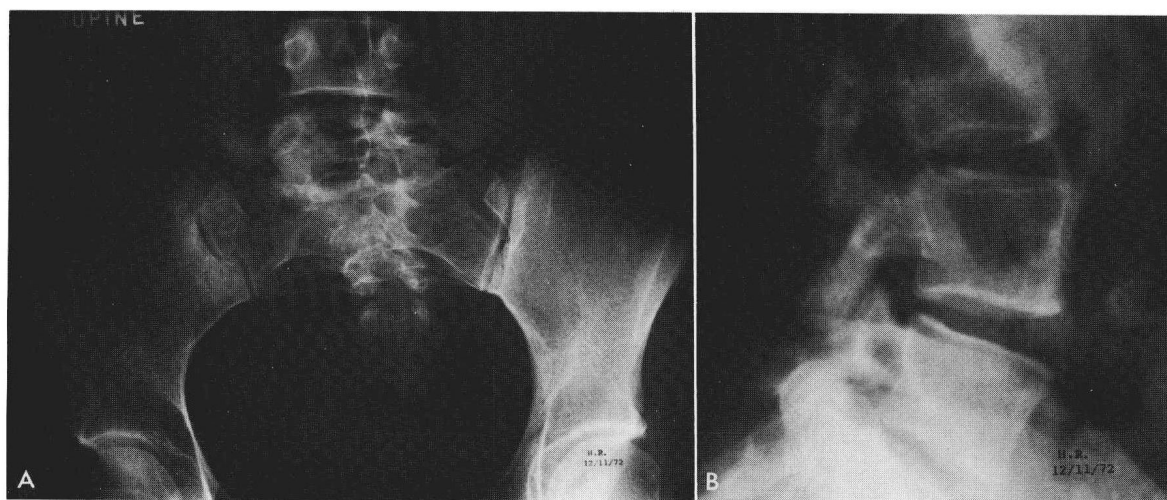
A*, Anterior posterior X-ray of the lumbar spine reveals a transitional fifth lumbar vertebra. *B*, Lateral view of the same patient reveals loss of height of the disc space between the transitional vertebra and the sacrum. This is not due to disc degeneration but rather to the congenital variation of the transitional vertebra.
